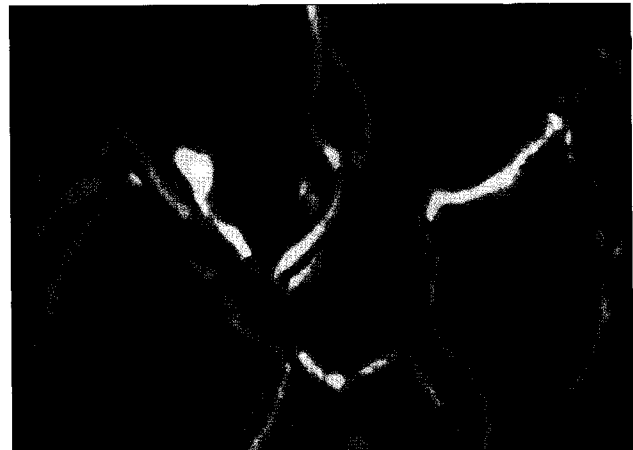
Computed tomographic angiography demonstrates an unruptured left middle cerebral and right posterior communicating artery aneurysms.
